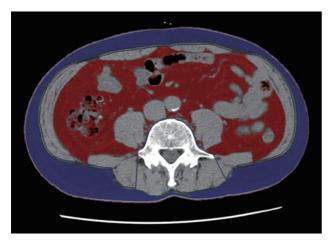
Method of measuring VFA and SFA on CT The VFA and SFA were measured at the level of the umbilicus on preoperative CT. The red and blue areas indicate the VFA and SFA, respectively. VFA, visceral fat area; SFA, subcutaneous fat area
